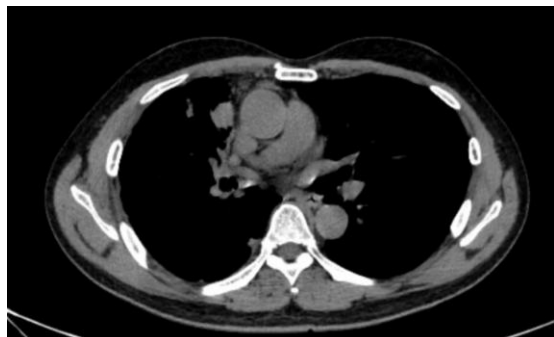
CT scan revealed a malignant-appearing mass in the right lung
